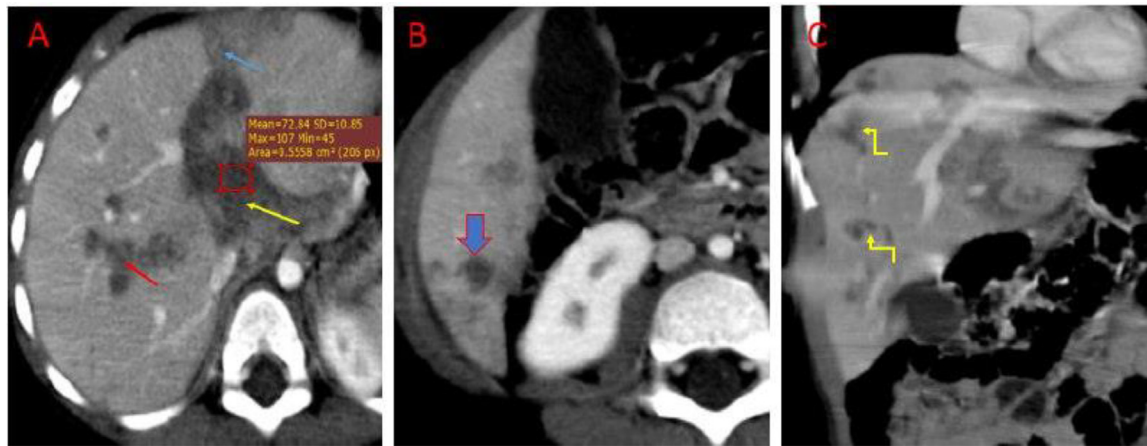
Postcontrast abdominal CT axial (A and B) and coronal (C) images: shows an enhancing hilar lesion (A: yellow arrow) which is continuous with the peripheral liver lesion (A: blue arrow). Biliary tree dilations and peripheral enhancement are demonstrated in image A (red arrow) and image C (yellow arrows). Peripheral parenchymal lesion in the posterior liver segment is shown in image B.
